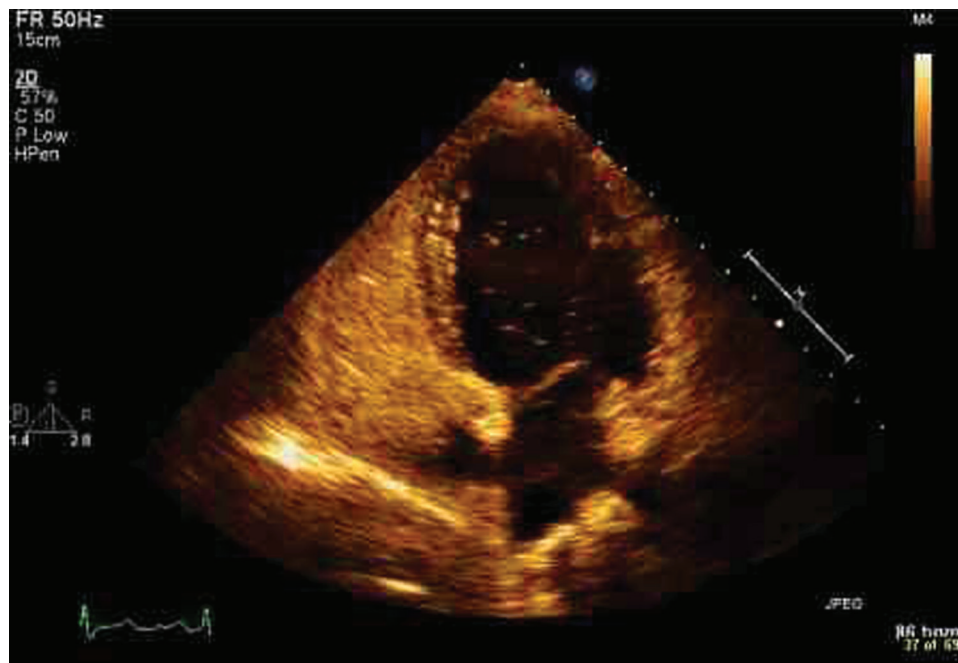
2D echocardiography demonstrating the PFO + ASA (arrow).
